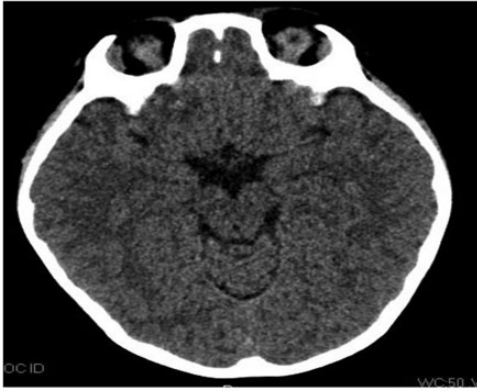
Axial computed tomography scan on postoperative day 1
